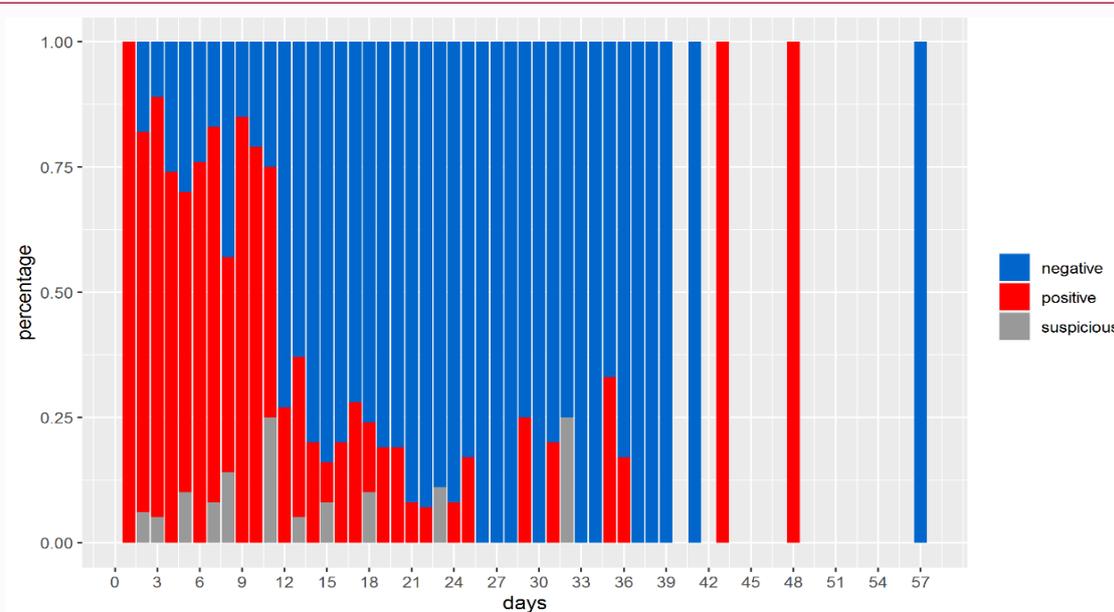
The trend of qualitative percentage of virus shedding with pharyngeal swabs. In the graph showing the qualitative CT value of virus shedding, which indicated the proportion of negative, positive and suspicious of nucleic acid in each day of clinical course in all patients. Nucleic acid positivity was high within first 10 days and decreased significantly from Day 11 to 14.
